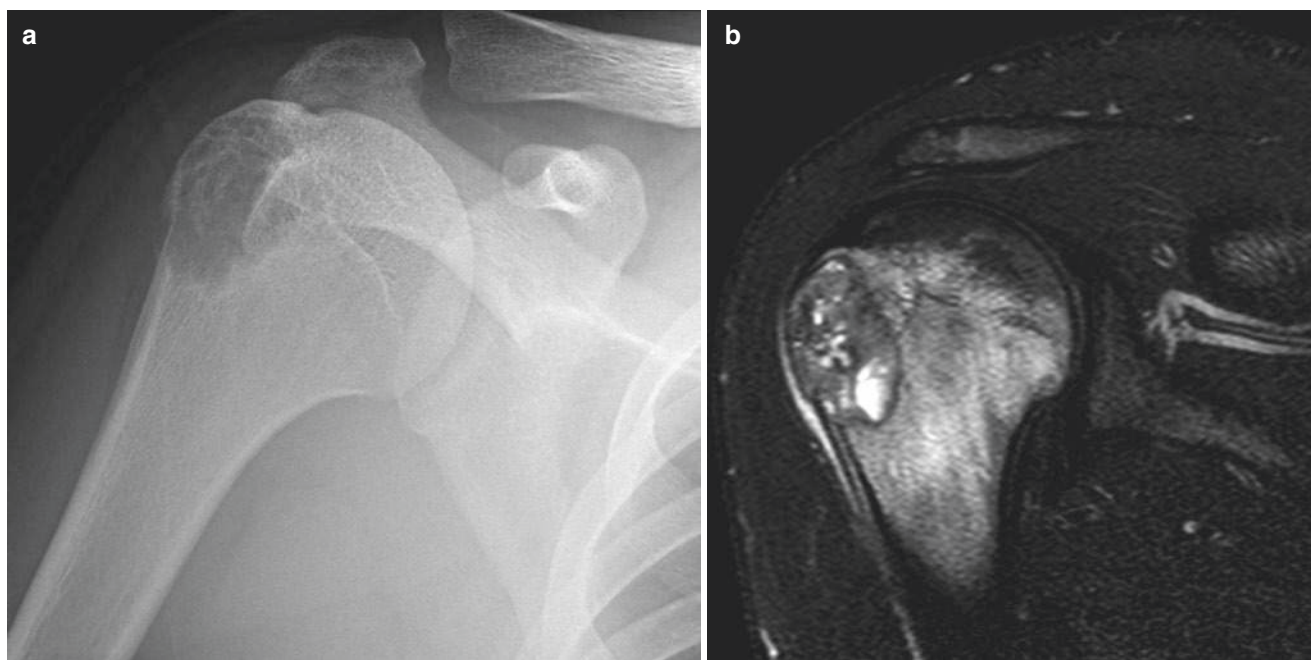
15-year-old boy with chondroblastoma. The patient presented with increasing shoulder pain over four months. (a) External rotation anteroposterior radiograph of the right shoulder shows a well-defined lucent lesion centered in the greater tuberosity of the proximal humeral epiphysis extending into adjacent metaphysis. (b) Fat-saturated
